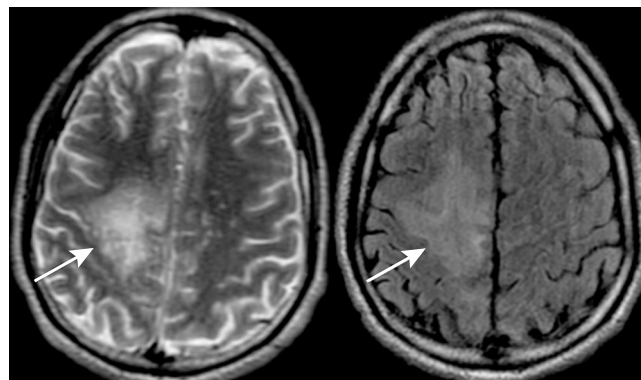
Brain MRI discloses subcortical lesions (hyperintense signal) with cortical preservation in a patient with JC virus infection.
